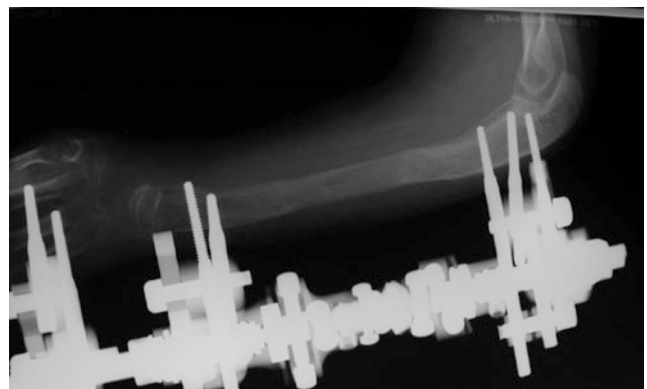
Radiograph during consolidation phase
